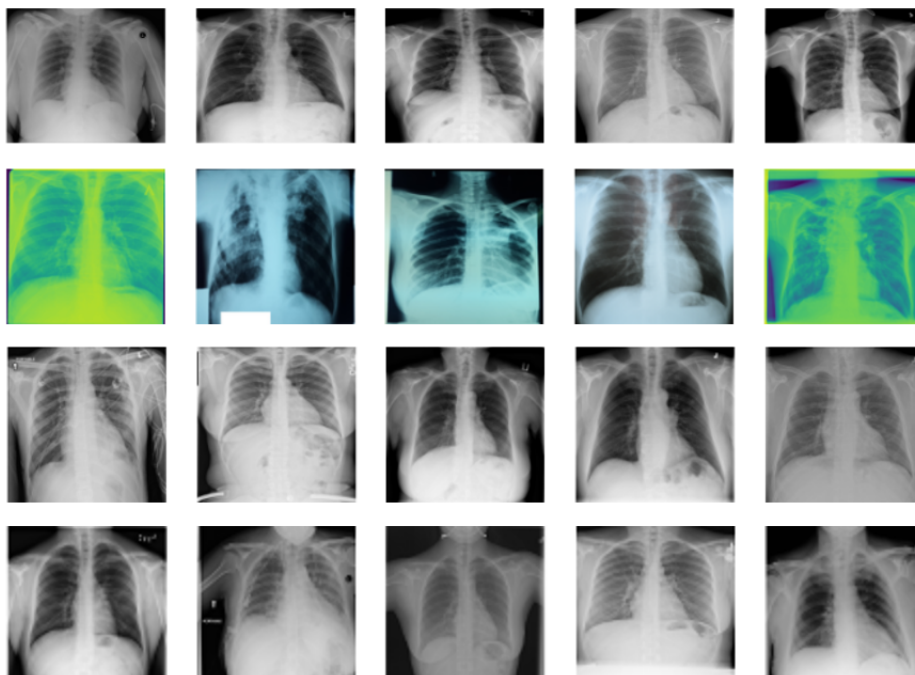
Tuberculosis (TB) Chest X-ray Database dataset examples
